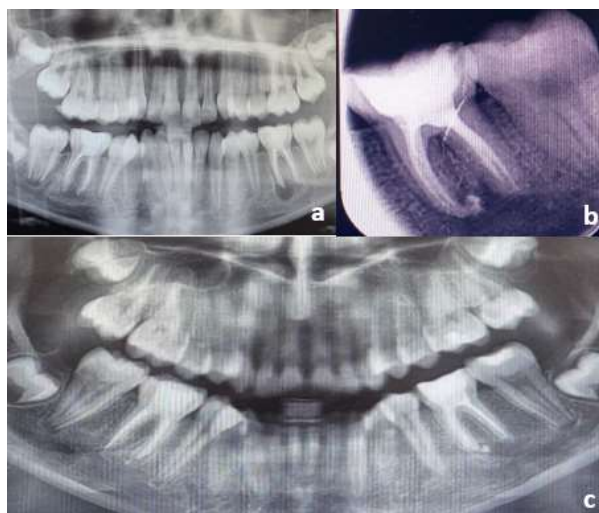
Pre-treatment radiographic view of Case 5 (a), after root canal repeat treatment (b) and Radiographic view after one year follow-up (c)
